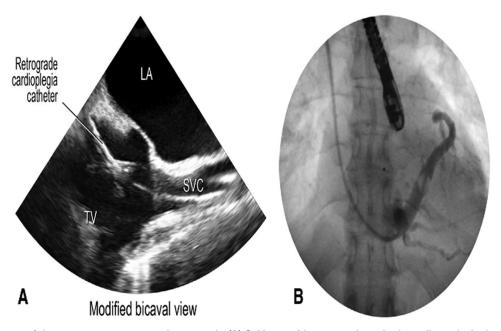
Placement of the percutaneous coronary sinus cannula. (A) Guidance with transesophageal echocardiography in the midesophageal bicaval view. (B) Guidance with fluoroscopy-the transesophageal echocardiography probe is also clearly visible.¹⁰ LA, left atrium; SVC, superior vena cava; TV, tricuspid valve.
